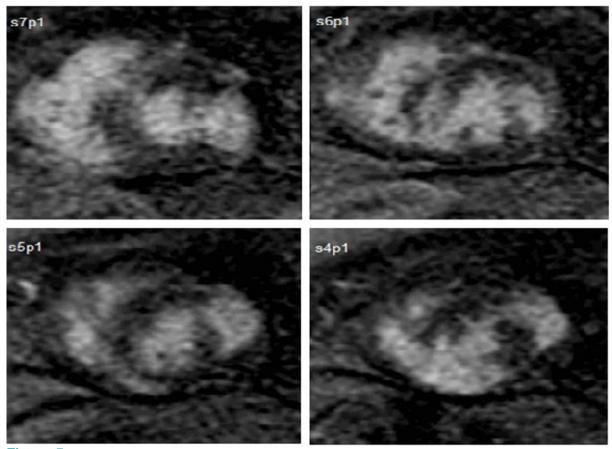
Cardiac MRI. Short axis view. Myocardial delayed enhancement (MDE). The dark areas present normal tissue. The patchy areas of MDE (white) depict areas of cardiac involvement in both lateral wall and septum.
